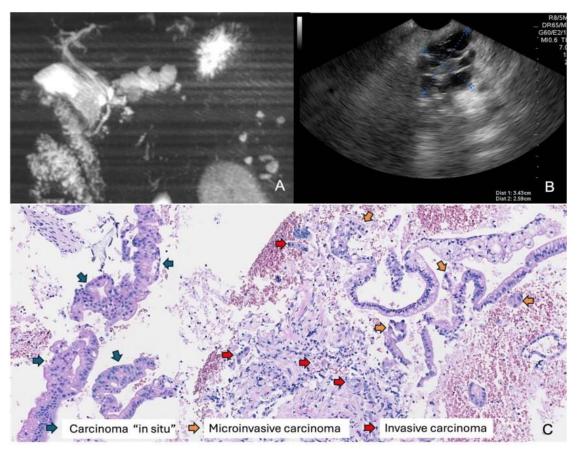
78 y-old asymptomatic woman. MRI performed during a check-up revealed multiple coalescent pancreatic cysts without worrisome features. Two years after starting follow-up, an MRI showed an increase in the coalescent cysts, and an EUS-FNA was indicated in other service. The cytology result was inconclusive, and the biochemical analysis revealed glucose < 40 mg/dL, CEA of 34.7, and amylase of 534 U/L. One year later, a follow- up MRI (A) showed an increase in the cystic. EUS-TA (B) was performed, and MCH analysis revealed well-differentiated invasive adenocarcinoma associated with IPMN in situ (green arrows), microinvasive (orange arrows), and invasive (red arrows) carcinoma.
